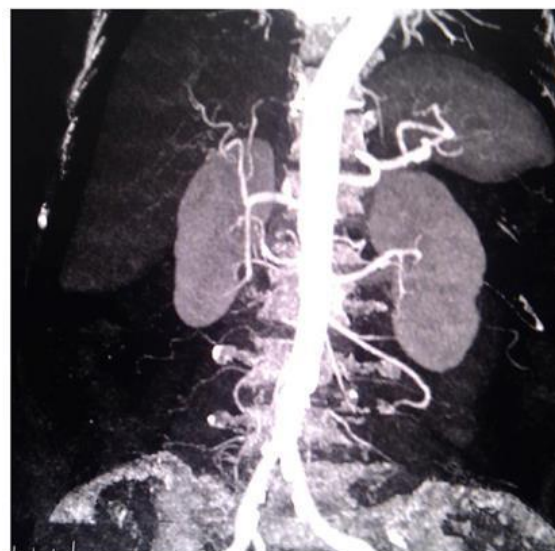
MIP Renal CTA- Left: Length x Height x Width (8.73 x 3.68 x 3.91 cm), main left renal artery diameter is 6.8 mm. Right: Length x height x Width (8.7 x 4.7 x 5.29 cm), main right renal artery diameter is 5.0 mm and accessory artery diameter is 2.8 mm.
